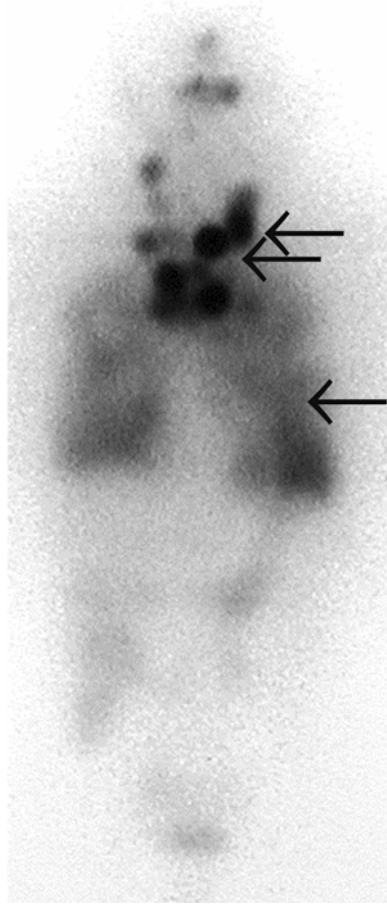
^{131}I whole-body scan of papillary thyroid cancer with regional adenopathy and diffuse pulmonary metastases. The patient was a 70-yr-old male presenting with right vocal-cord paralysis from a 5.0-cm primary papillary thyroid carcinoma invading the right laryngeal nerve. A ^{131}I whole-body scan was done 48 h after a dose of 2 mCi of ^{131}I . ^{131}I uptake is seen in multiple metastatic lymph nodes in the cervical neck and upper mediastinum, as well as in diffuse pulmonary metastases not seen on a CT scan. Single arrow: diffuse uptake of ^{131}I in the lungs, by micrometastases. Double arrow: regional metastases in the cervical neck and upper mediastinum.
